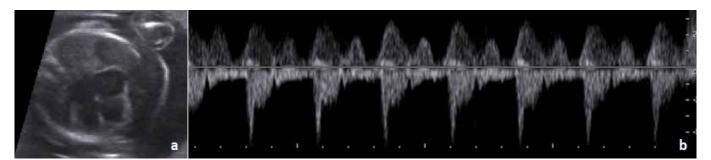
Diastolic dysfunction in a fetus with hemolytic anemia at 35 weeks of gestation, cardiomegaly (CFI 0.65). In the spectrum of the pulmonary vein (above the isoline), there was a decrease in the ratio of the velocity at the point of opening of the atrioventricular valve to the maximum velocity during ventricular diastole AVO/S0.25 (0.42–0.74) and an increase in atrial time A dur 207 ms (109–205 ms). a) cardiomegaly b) Doppler spectrum of pulmonary artery and vein
